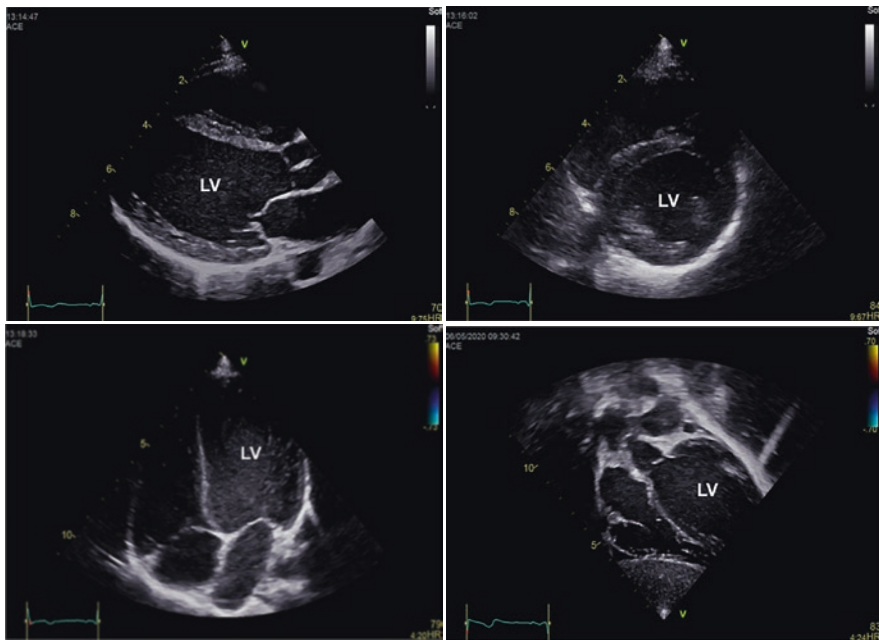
Different echocardiographic views commonly used for qualitative left ventricular systolic estimation: parasternal long and short axis view, apical 4-chamber view, and subcostal view (good view to assess function during cardiac massage)
